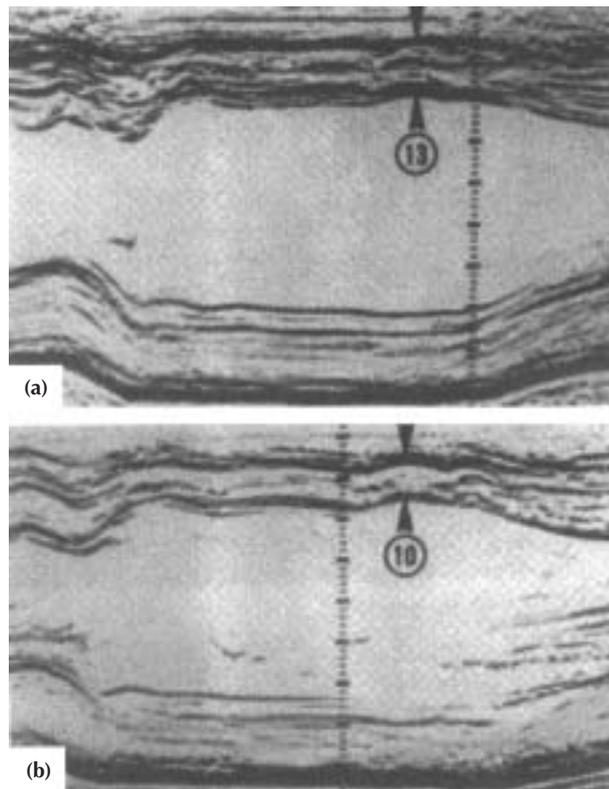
M-Mode echocardiographic tracings obtained from an elite male rower, (a) at the peak of athletic conditioning and (b) after an 8-week period of deconditioning. The ventricular septum shows a reduction in thickness from 13 mm (a) to 10 mm (b). (From PellICCia and Maron [1], with permission.)
